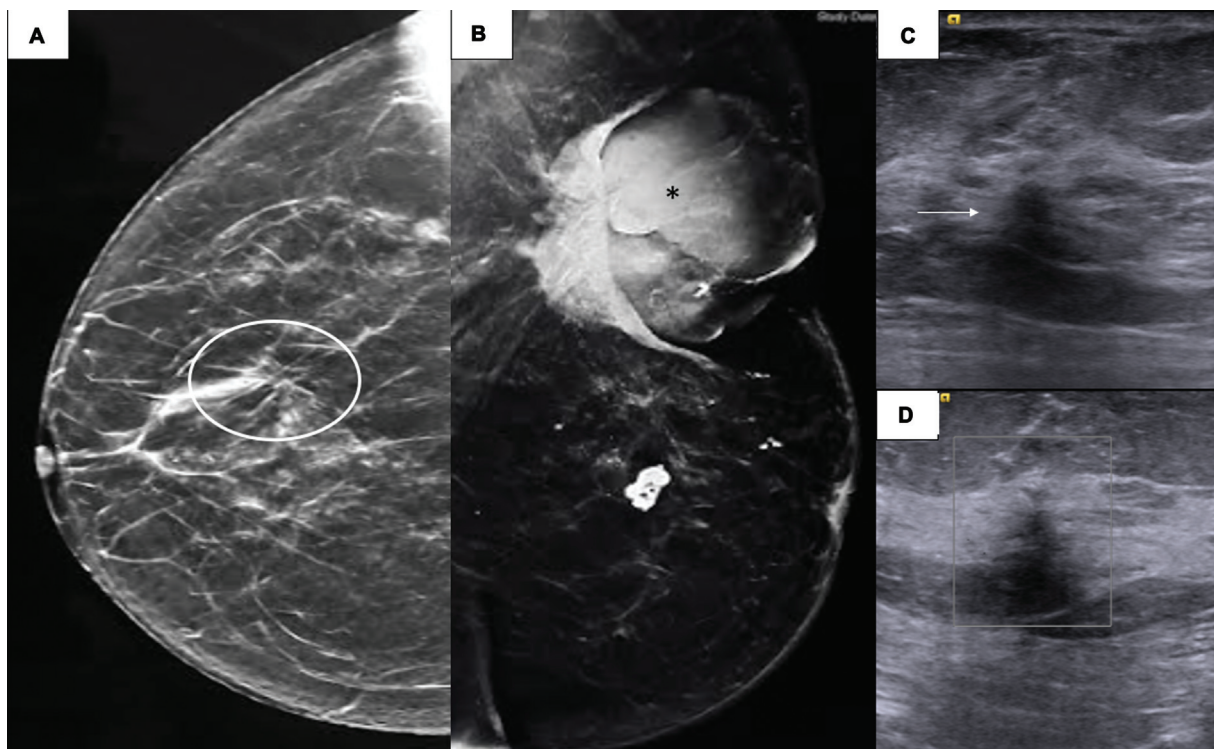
Low-grade ductal carcinoma in situ (DCIS) as nonmass finding. Mammogram of a 56-year-old female with proven malignant mass in left breast (asterisk in B) incidentally revealed focal architectural distortion in central quadrant of right breast on craniocaudal view (circled in A). Subsequently performed ultrasound (US) showed a focal area of architectural distortion with posterior shadowing which was subjected to US-guided biopsy and proven to be low-grade DCIS.
